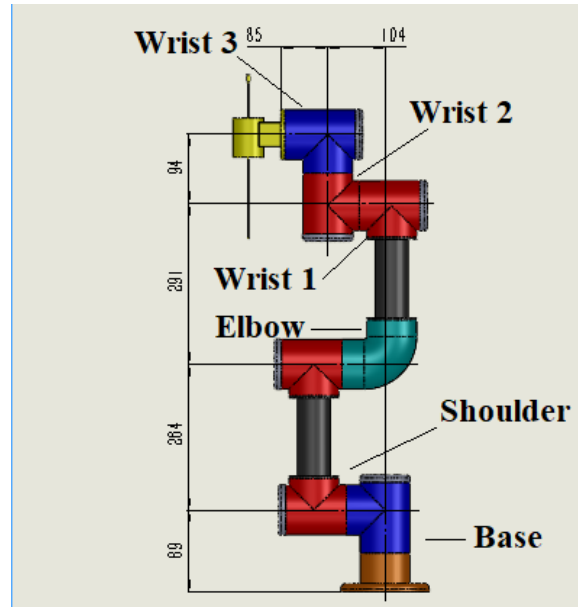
3D model and dimensions of proposed MRI-guided robot manipulator
